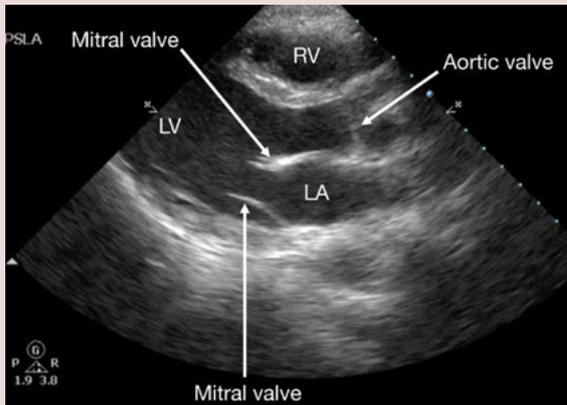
Parasternal long view: LV = left ventricle, RV = right ventricle, LA = left atrium.
